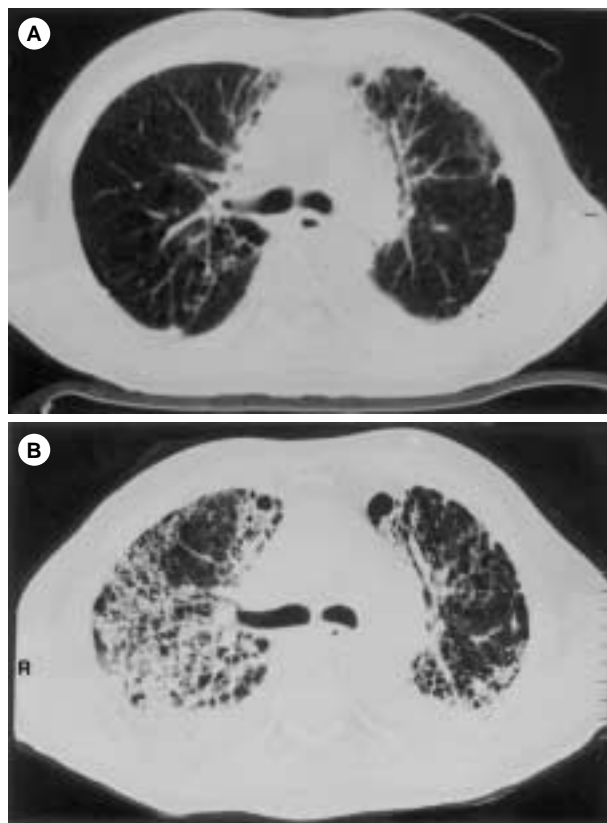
Serial chest computed tomographs of case 3. (A) The chest computed tomograph was taken on November 5, 1999, when the 6 courses of chemotherapy with docetaxel and gemcitabine had just finished. This film shows mild fibrotic changes in both lungs that were compatible with radiation pneumonitis (6 months after finishing chest radiotherapy). (B). The chest computed tomograph was taken on November 30, 1999, one day after his last admission, when he developed severe hypoxemia and respiratory failure. This film shows coarse reticular interstitial and nodular infiltrations in the right lung field and left perihilar region that were compatible with hypersensitivity pneumonitis. Because of the rapid progression of the interstitial process, disseminated malignant disease or other systemic disease was excluded first; in addition to exposure history, clinical course, and laboratory data, including transbronchial lung biopsy, docetaxel-induced hypersensitivity pneumonitis was diagnosed
